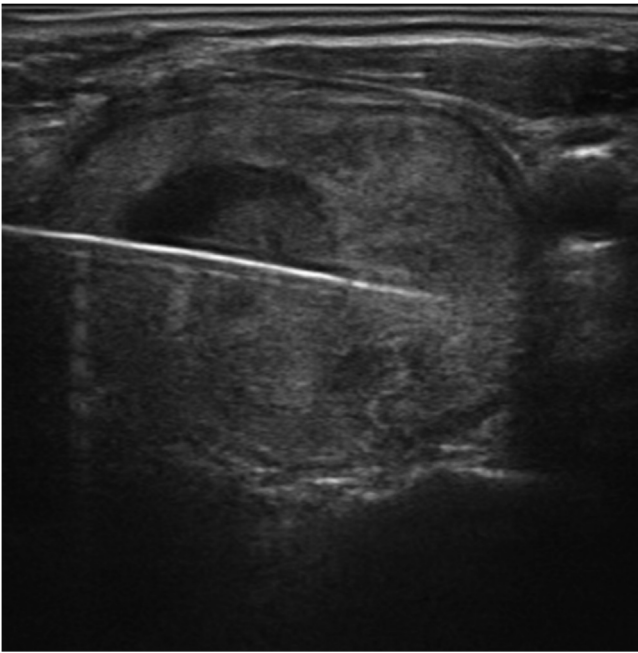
Ultrasound-guided probe positioning.
